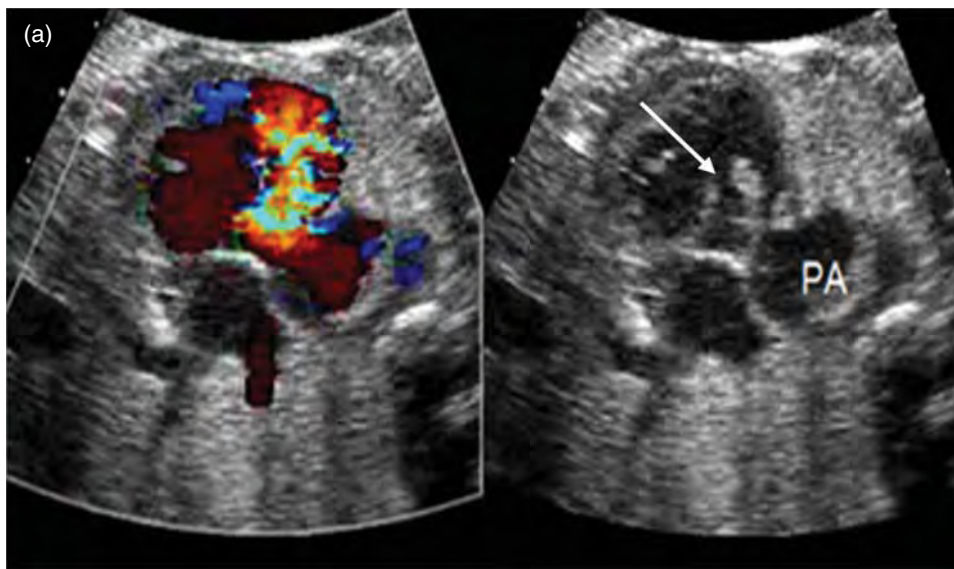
Tetralogy of Fallot with absent pulmonary valve syndrome. (a) Anterior malalignment ventricular septal defect (VSD; arrow) and free pulmonary regurgitation (color) cause progressive dilatation of the proximal pulmonary arteries (PA) which can result in significant compression on the tracheal–bronchial tree and esophagus. (b) Free pulmonary regurgitation shown by Doppler across the RV outflow tract.
